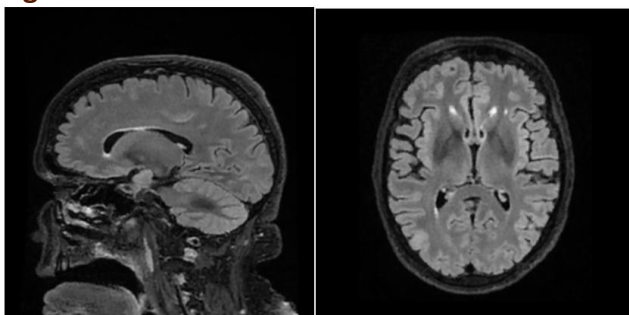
Sagittal and Axial T2 Flair sequence image of MRI brain showed hyperintense foci in deep white matter and periventricular areas.
